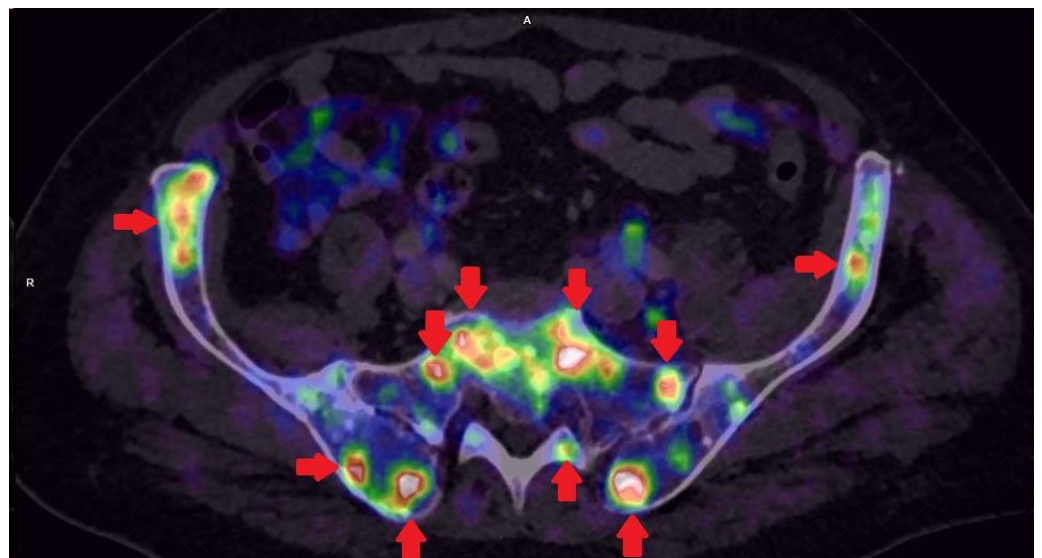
Patient with multiple bones metastases in prostate cancer GS 8 (4 + 4) iPSA 45.33 PHI 176.8 in [^{68}Ga]-PSMA-11 PET/CT.
